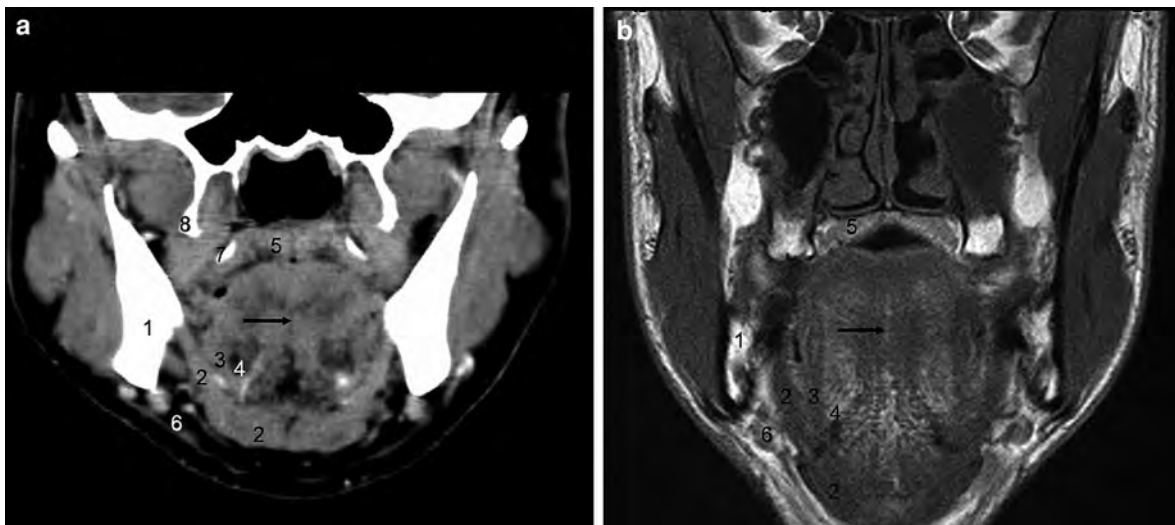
Coronal CT (a) and MRI (b) at more posterior aspects of the oral cavity. 1 mandible, 2 mylohyoid muscle, 3 hyoglossus muscle, 4 sublingual fat space (with lingual artery and vein), 5
